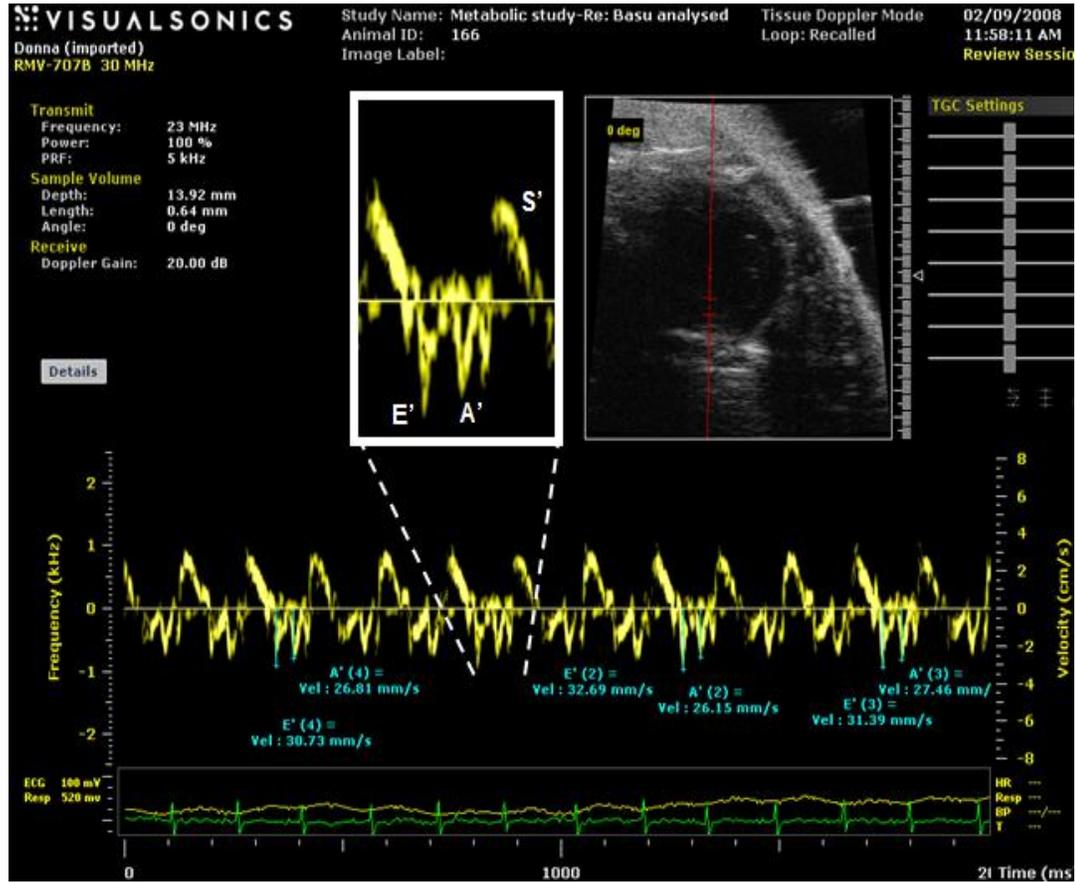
Representative image of the tissue Doppler imaging (TDI) signal detecting lateral annular motion at the mitral valve.
